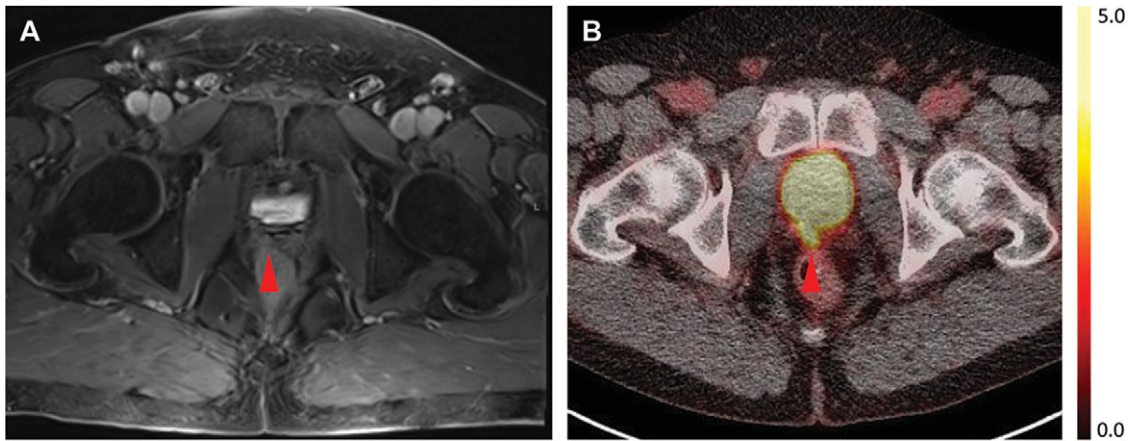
(A) Axial T1-weighted postcontrast MRI and (B) axial [¹⁸F]DCFPyL PET/CT images through the prostate bed demonstrating the patient's presumed local recurrence as intense radiotracer uptake on PET/CT but with no corresponding abnormality on MRI. The relative radiotracer uptake in the prostate bed lesion is visually and quantitatively higher than the uptake in the sacrum shown in Figure 1D–E.
